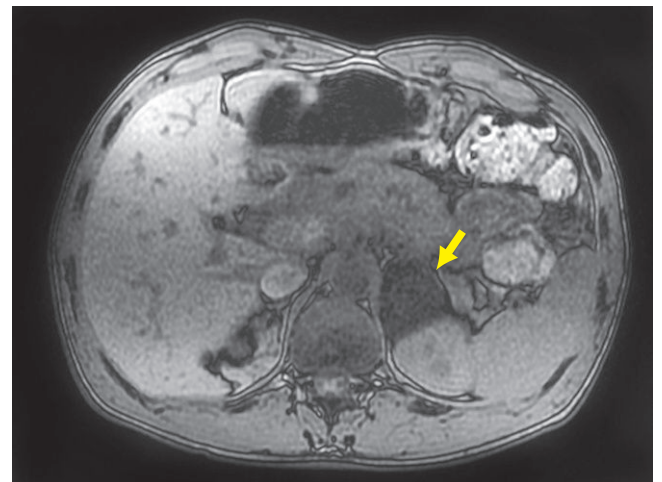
Out-of-phase MRI of left adrenal with signal dropout (arrow), which is seen with adrenal adenomas.
